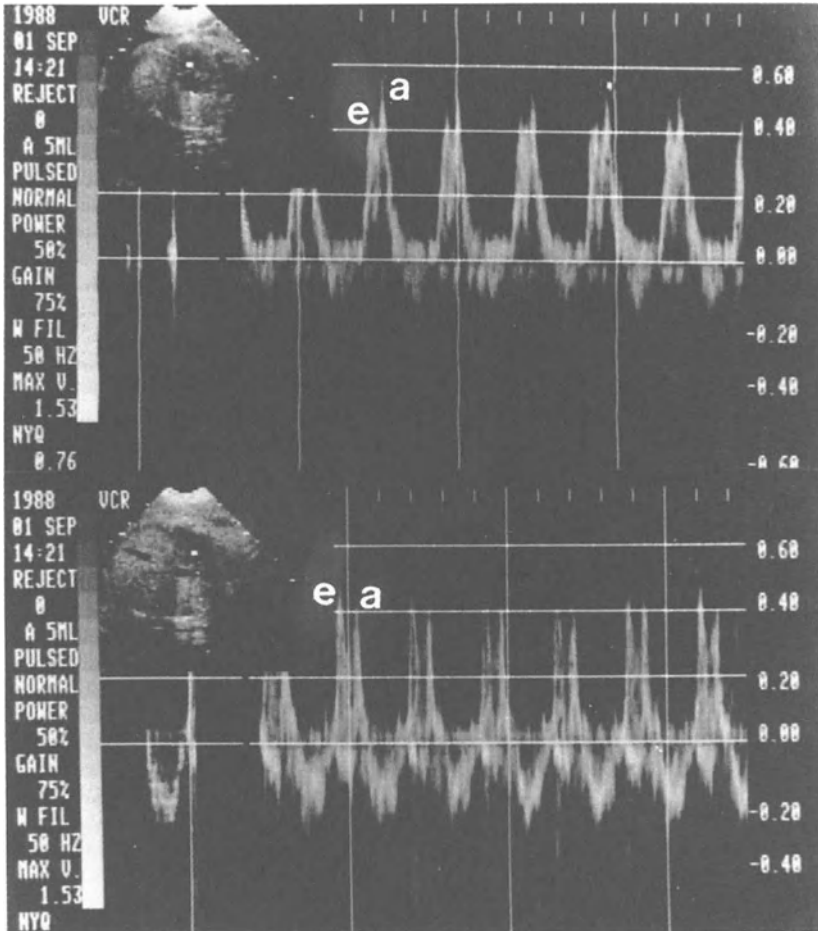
Doppler echocardiography of the atrioventricular waveform. (A) The right ventricular Doppler waveform. (B) The Doppler waveform from the left ventricle. A indicates flow velocity due to atrial systole; E indicates initial ventricular inflow deflection.
